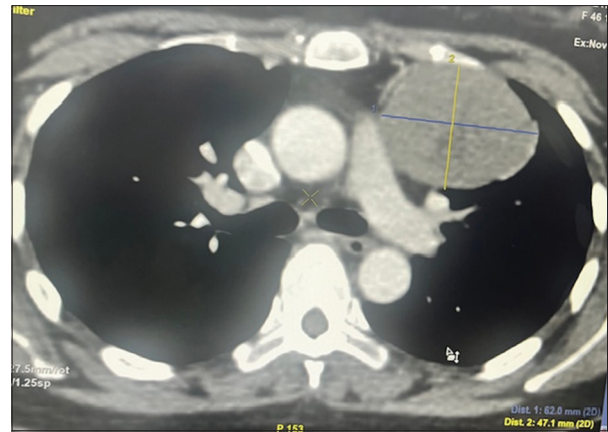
Post-chemotherapy contrast-enhanced computed tomography image demonstrating an interval increase in size of the anterior mediastinal mass
